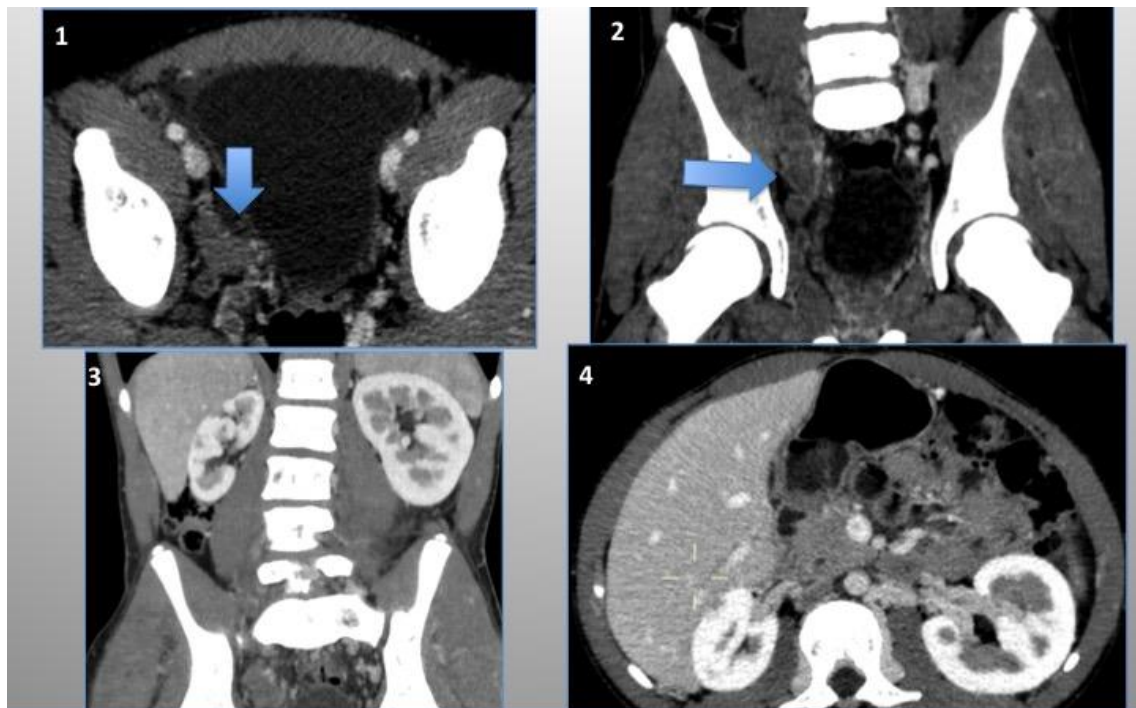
Contrast enhanced CT . Acute venous thrombosis of right common iliac vein, internal and external iliac veins and pelvic veins (arrows). Fig. 3 and 4: Right renal atrophy due to thrombosis of the renal vein in the neonatal period. Chronic inferior vena cava thrombosis with development of paravertebral venous colaterals.
